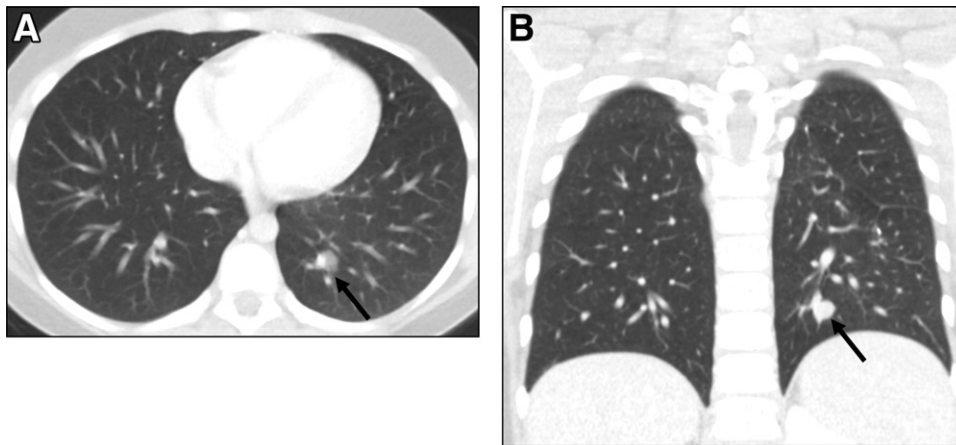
A 10-year-old girl (weight, 42 kg) with a history of metastatic rhabdomyosarcoma underwent follow-up chest CT at 100 kVp, 80 mA, a noise index of 14.1, and pitch of 1.375 (volume CT dose index, 1.5 mGy; dose-length product, 49 mGy · cm; estimated effective radiation dose, 0.7 mSv). Transverse (A) and coronal (B) chest images reconstructed with Adaptive Statistical Iterative Reconstruction demonstrate new nodular opacity in left lower lobe (arrows).
